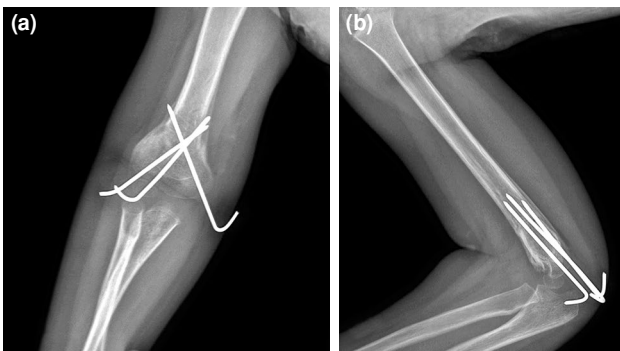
(a) Anteroposterior and (b) lateral radiographs showing loss of reduction in the third week.
